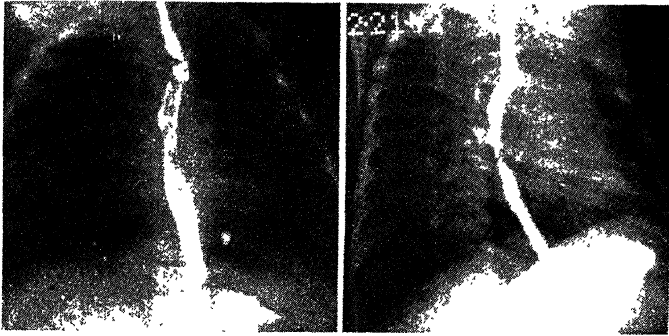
X-ray examination 11½ months after operation. There is no dilatation of the upper portion of the œsophagus. The lumen of the œsophagus at the level of the stricture is larger than in *Fig. A* and is considerably less curved.
